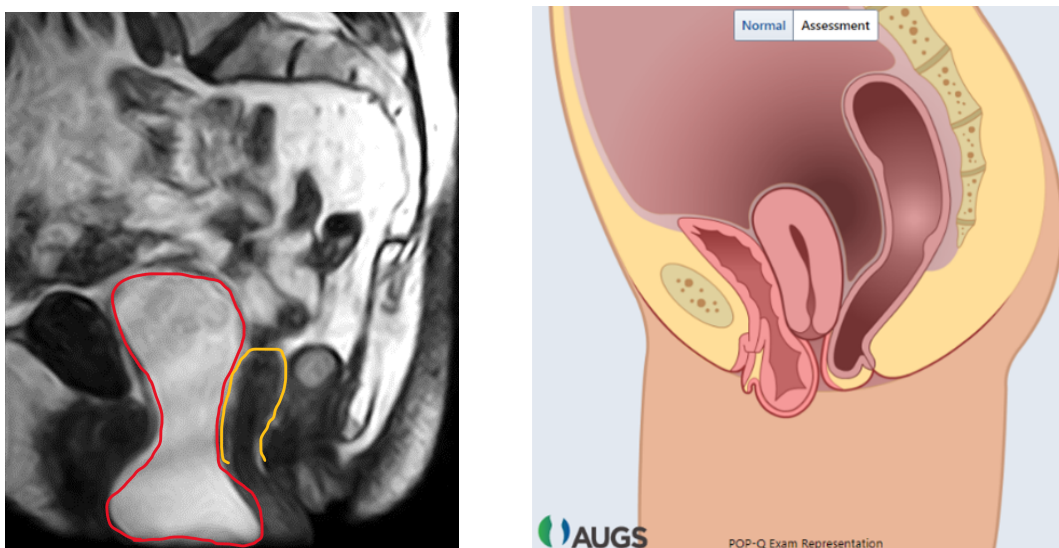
Comparison of MRI scans and AUGS tool with “large” difference in uterus location and size: The first image shows the MRI scan upright in rest, with the red outlined bladder and yellow outlined uterus. The uterus is smaller in size compared to the AUGS tool; the uterus is also positioned lower.
